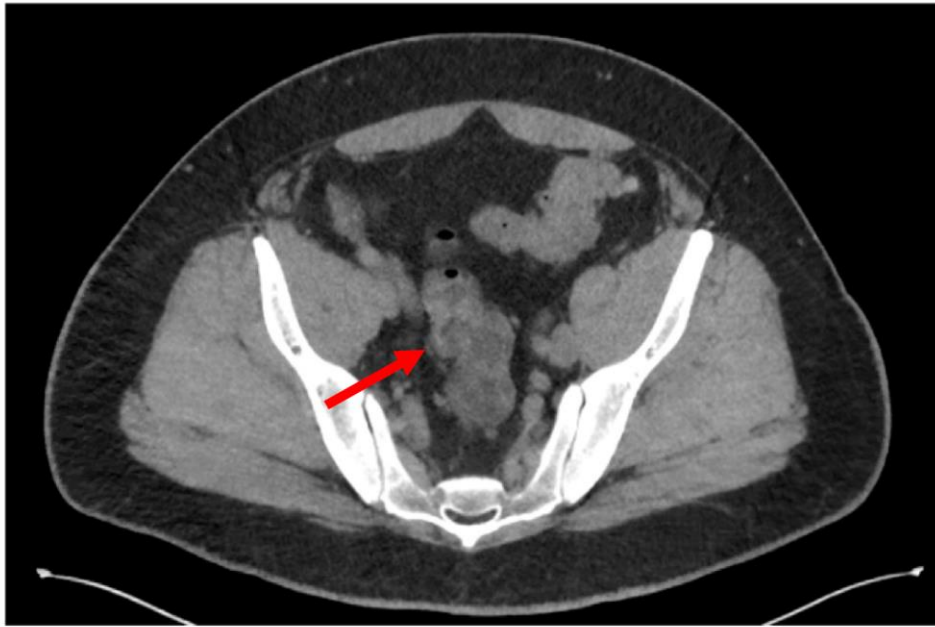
Computed tomography of patient with mild colonic mural thickening in the sigmoid colon (i.e. arrow).
